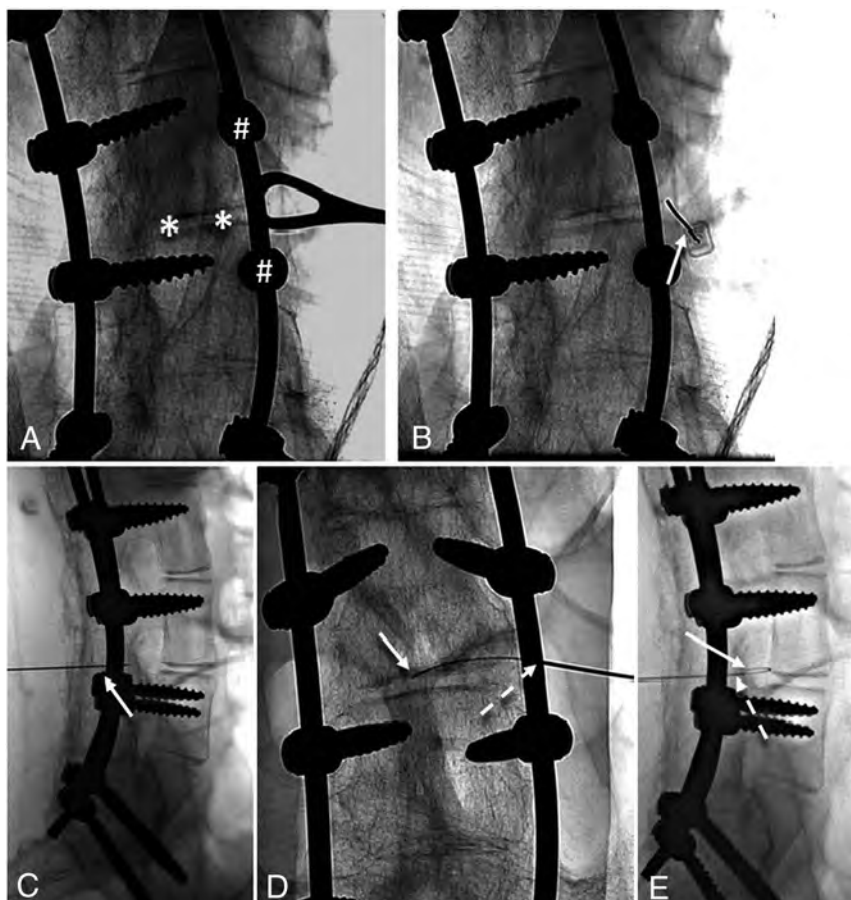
Spot radiographs demonstrating steps in TFLP using the curved Pakter needle. A, posterolateral oblique view along the long axis of the pedicle. A ring forceps indicates the skin entry site at the level of the disk (asterisks), just lateral to the pedicles (hashtags). B and C, posterolateral oblique and lateral views show the correct position of the outer guiding needle terminating just lateral to the posterior margin of the target neural foramen and projecting over the lateral disk margin on the posterolateral oblique view (arrow). D and E, posteroanterior and lateral views show the correct position of the outer needle (dashed arrow) and the inner curved needle (solid arrow), having passed through the target neural foramen and terminating within the thecal sac at L3–4.
